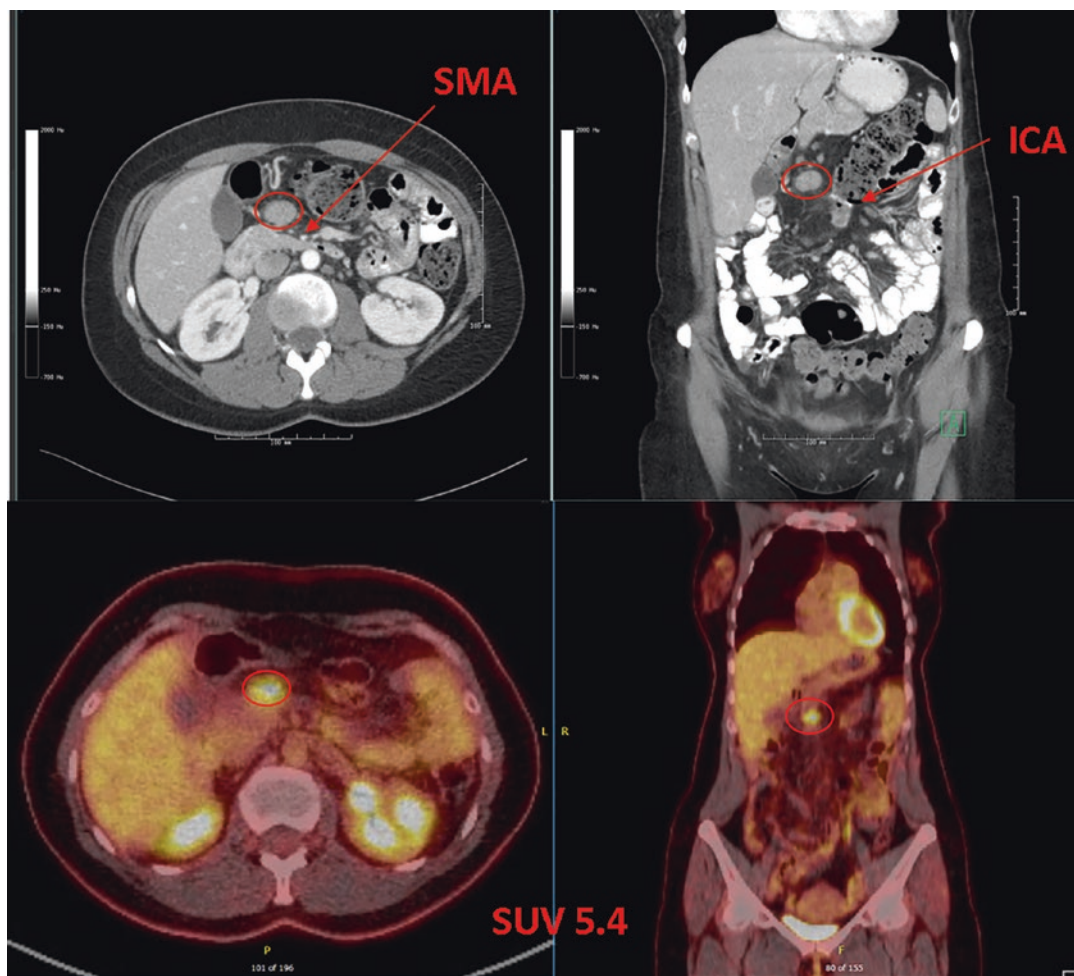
Imaging one year following right hemicolectomy for hepatic flexure adenocarcinoma: CT with contrast and subsequent PET/CT demonstrating FDG avid
